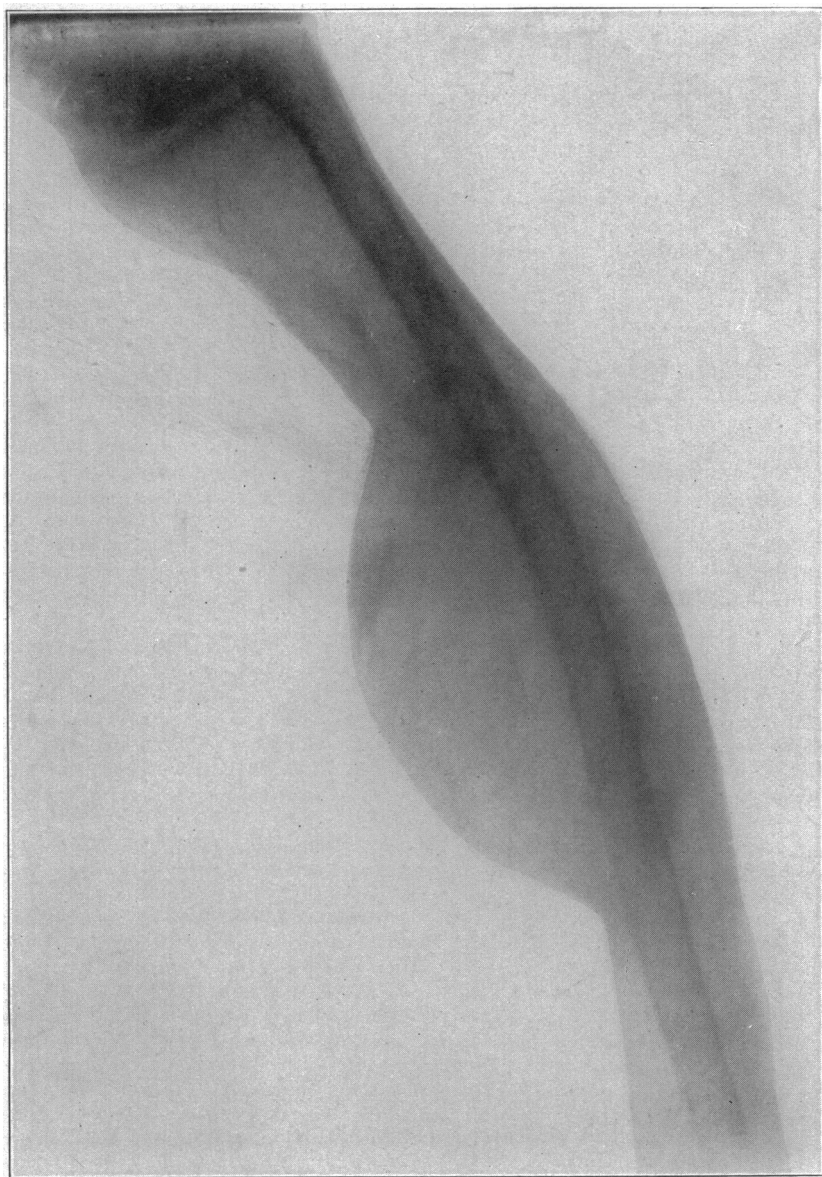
X-ray plate showing bony tumor from the left shin of a patient suffering from osteomalacia.
